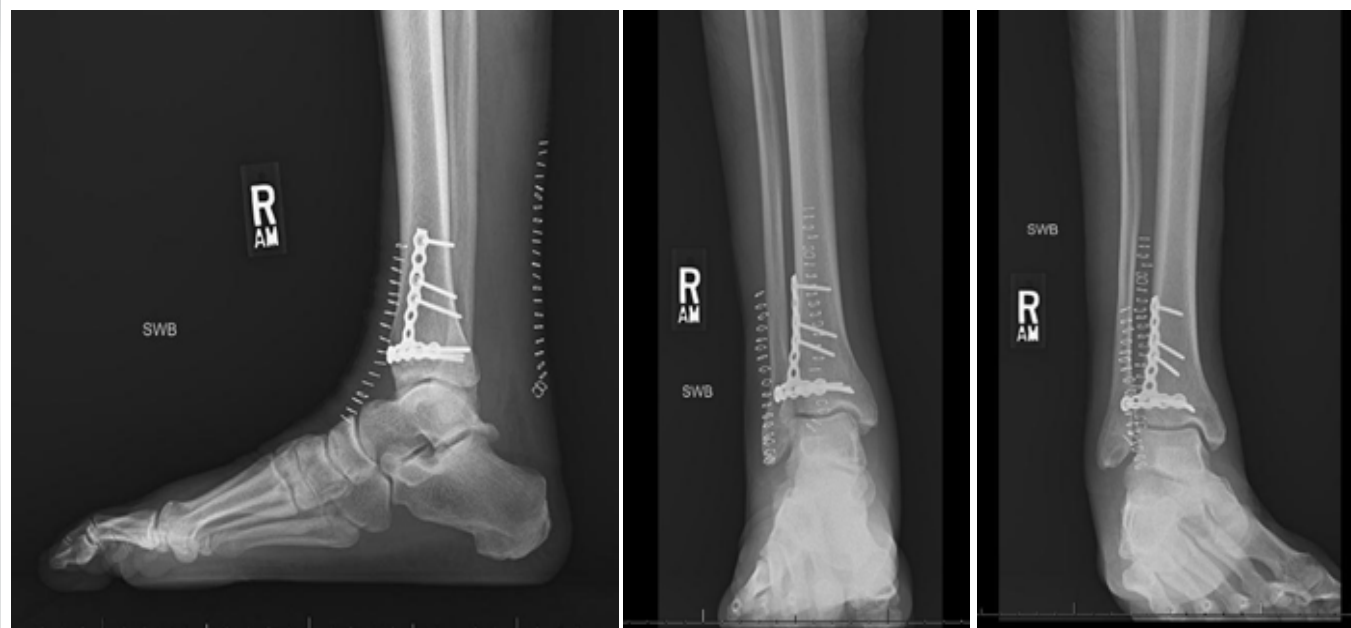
2 Week post-operative radiographs: 2 week post-operative X-rays showing a healing fracture and intact hardware.
